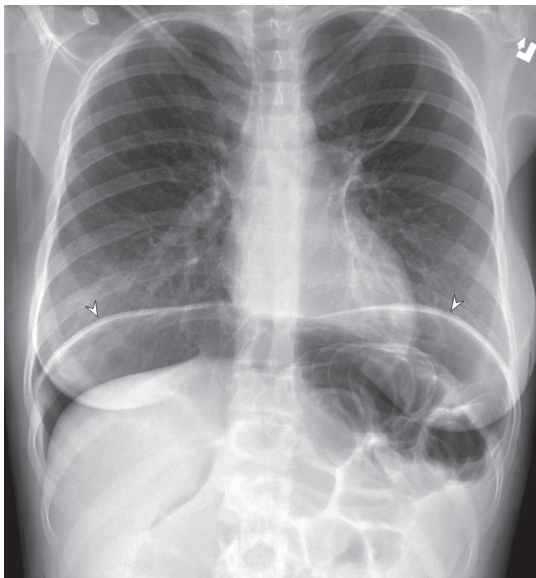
Pneumoperitoneum from bowel perforation on conventional radiographs. Upright radiograph shows the large amount of free intraperitoneal air (lucent area just inferior to the diaphragm). (From Goldman. *Goldman's Cecil medicine*. 24th ed. Philadelphia: Saunders, 2011, Fig. 135-1.)
